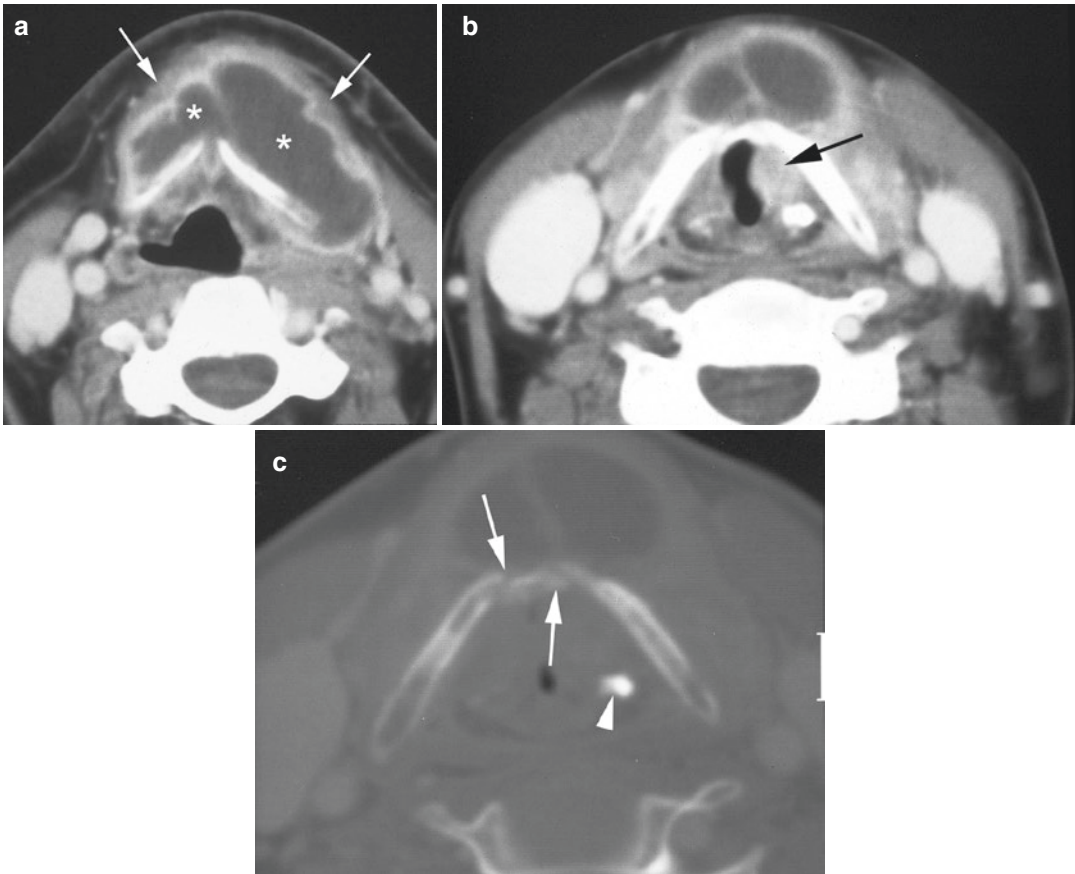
Axial contrast-enhanced CT images. (a) Supraglottic level. Large fluid collection (stars) with rim enhancement is seen in the prelaryngeal soft tissues, displacing the strap muscles (arrows) anteriorly. (b) Glottic level. The large fluid collection extends downwards to
